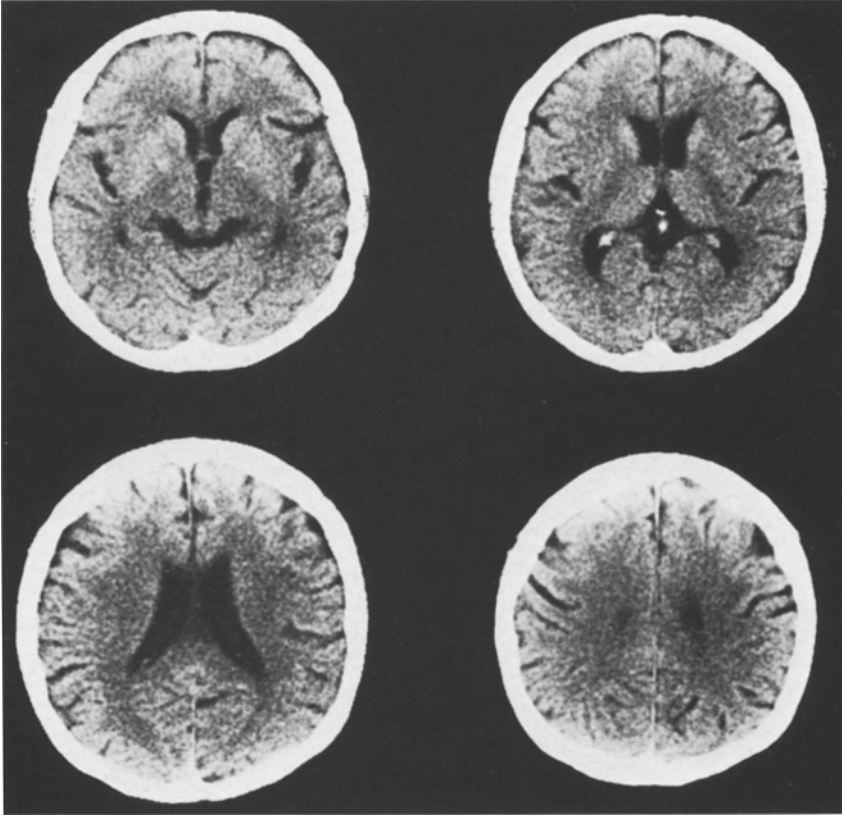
CT of a stage I patient
